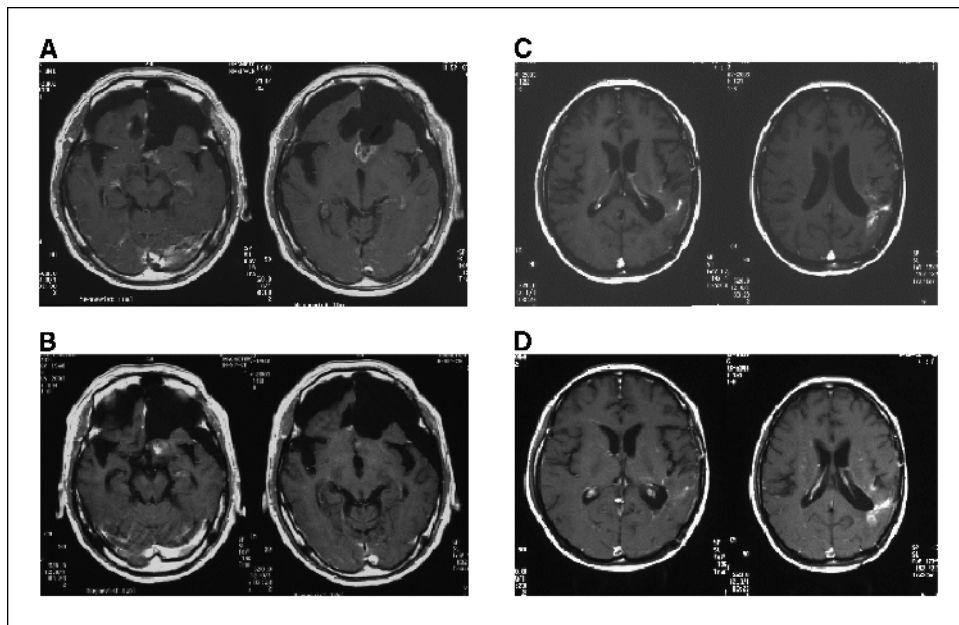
MRI contrast-enhanced images of case 12 before (A) and after (B) vaccination showing that the fronto-basal lesion was decreased after vaccination. MRI contrast-enhanced images of case 22 before (C) and after (D) vaccination showing that the size of the contrast-enhanced left temporo-parietal area was stable for 1 year after vaccination.
